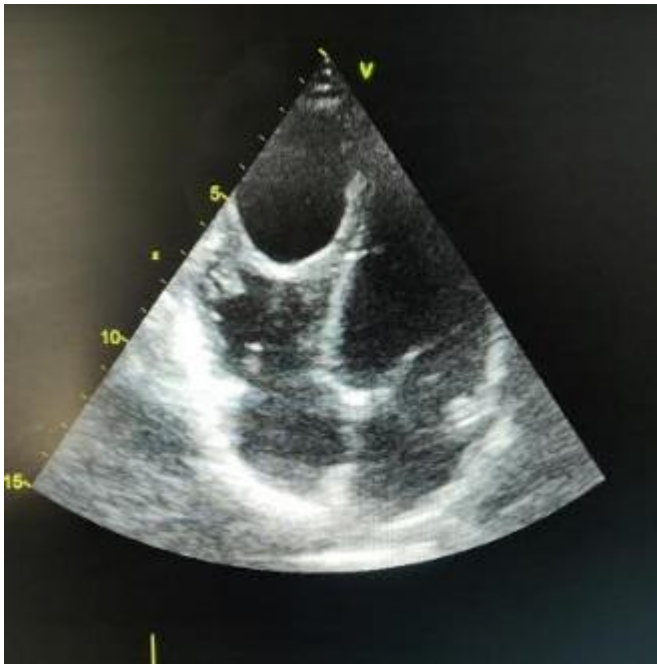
apical four chambers Transthoracic echocardiography showing hydatid cyst image in right ventricular apical region
